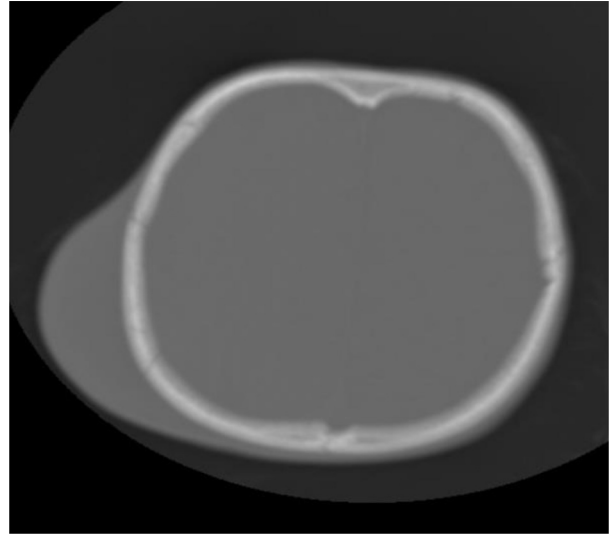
Axial computed tomography scan image with bone window settings indicating right parietal linear fracture.
